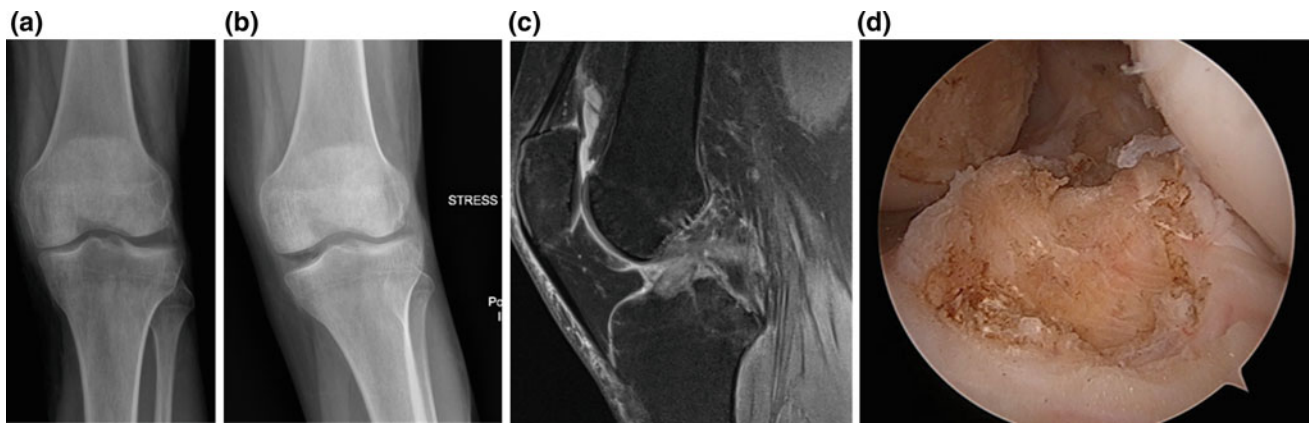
AP (a) and AP stress (b) radiographs of patient RB presents with what was recognized as a KDIV but had some evidence of ACL function. Stress views document both corners injured, MRI (c) with injury to the ACL and reconstruction required of all ligaments (d)
